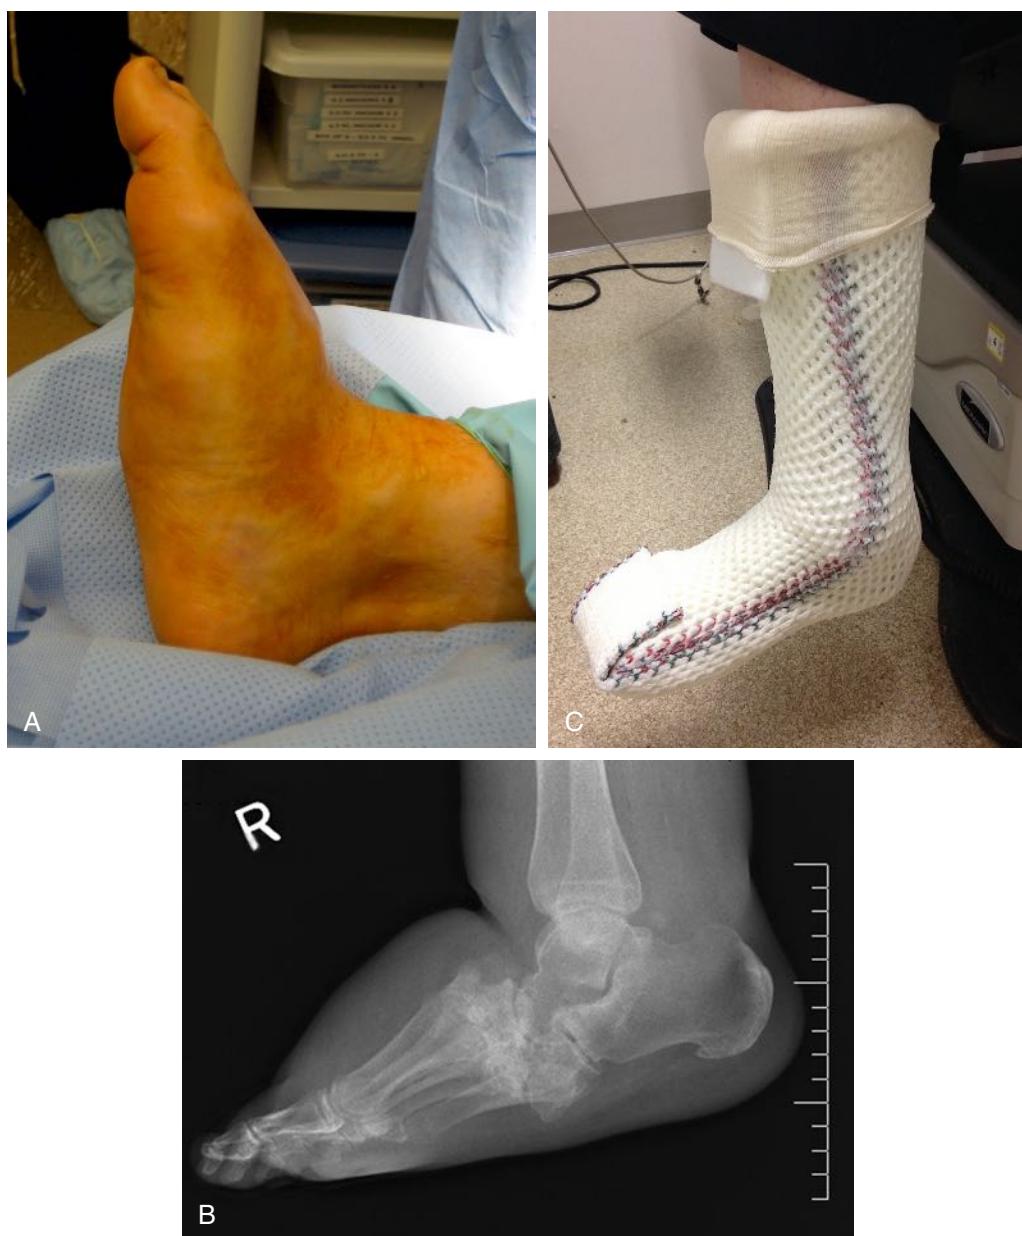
Charcot foot; typical “rocker bottom” appearance (A), characteristic X-ray (B), and offloading with total contact cast (C).
